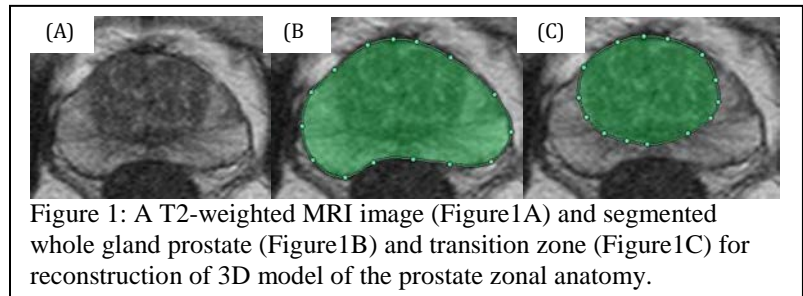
A T2-weighted MRI image (Figure1A) and segmented whole gland prostate (Figure1B) and transition zone (Figure1C) for reconstruction of 3D model of the prostate zonal anatomy.
